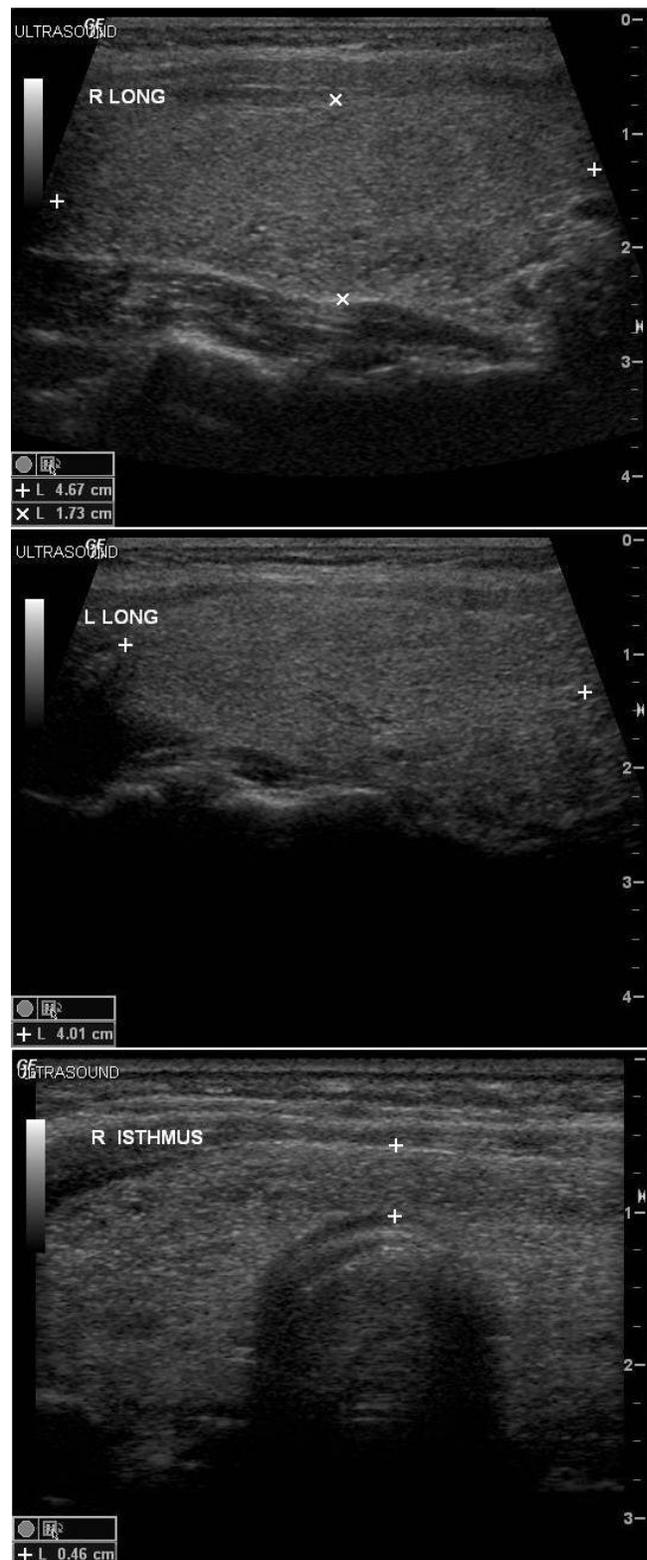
Grayscale thyroid ultrasonography of the patient while being treated with lithium showing diffuse thyromegaly
